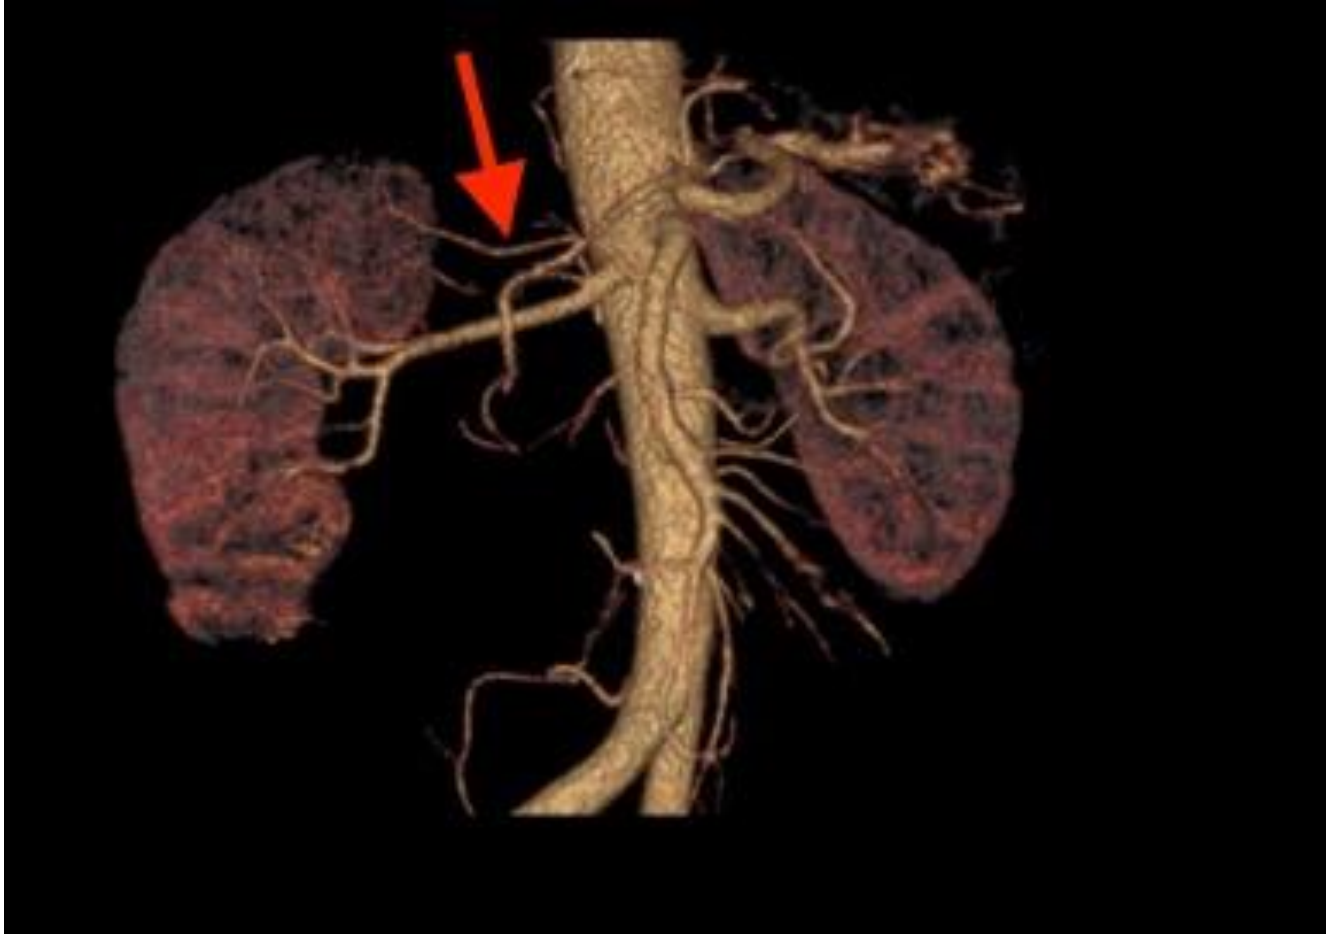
Polar artery of the right kidney in computed tomography angiography image (Red arrow)
